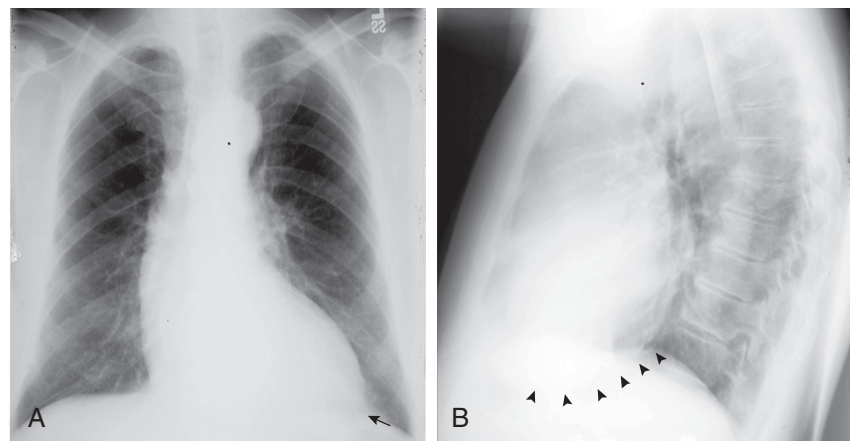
Chest radiographs of a 63-year-old man with chronic aortic regurgitation. A, PA view showing downward displacement of the apex (arrow), suggestive of LV enlargement. There is prominence and enlargement of the ascending aorta, which has created a convex right border of the mediastinum. B, Lateral view showing prominent LV enlargement (arrowheads). The aortic root is markedly enlarged in the retrosternal airspace but is separate from the sternum (in contrast to the findings with RV enlargement; see Fig. 15-10B).
